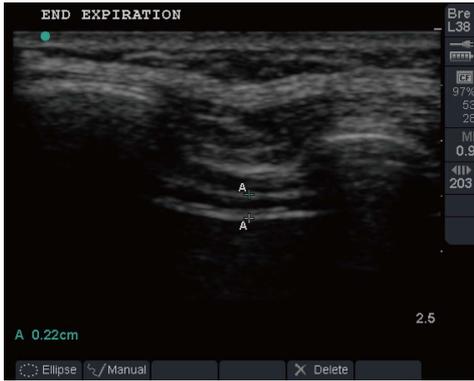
Ultrasonography image of a patient taken at end expiration. Diaphragm identified as the last set of parallel line, pleural and peritoneal membranes overlying the less echogenic muscle.
